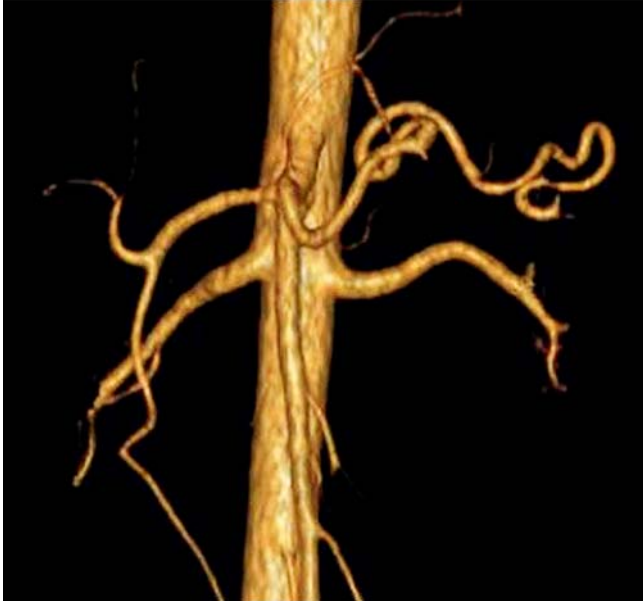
Three-dimensional (3D) computed tomography (CT) angiogram taken 4 months later showing the splenic artery without the pseudoaneurysm sac.
